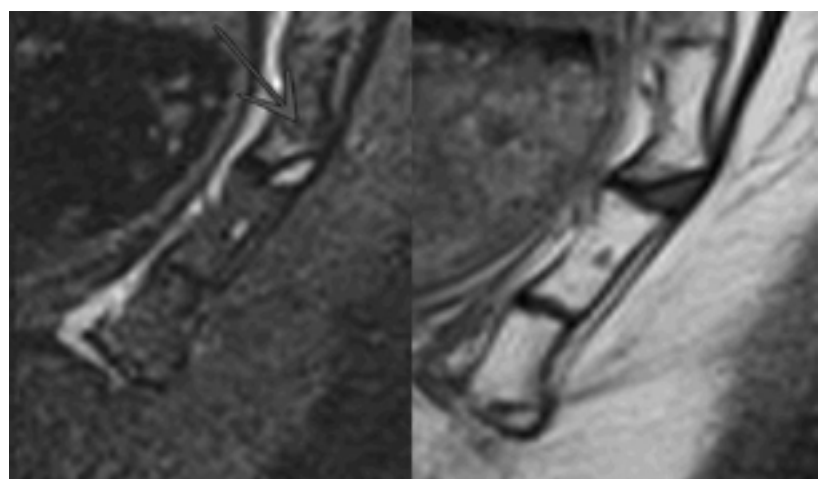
Sagittal STIR (right) and T1 (left) MRI. Well-defined cystic image developed from the disc, eroding the posterior part of the overlying vertebra, with inflammation of the anterior part (T2 hypersignal). The discontinuous image within the apex, hypointense on T1, could reflect a non-consolidated fracture but there is no hypersignal in T2. It is therefore more likely to be a congenital aspect of partial segmentation.
